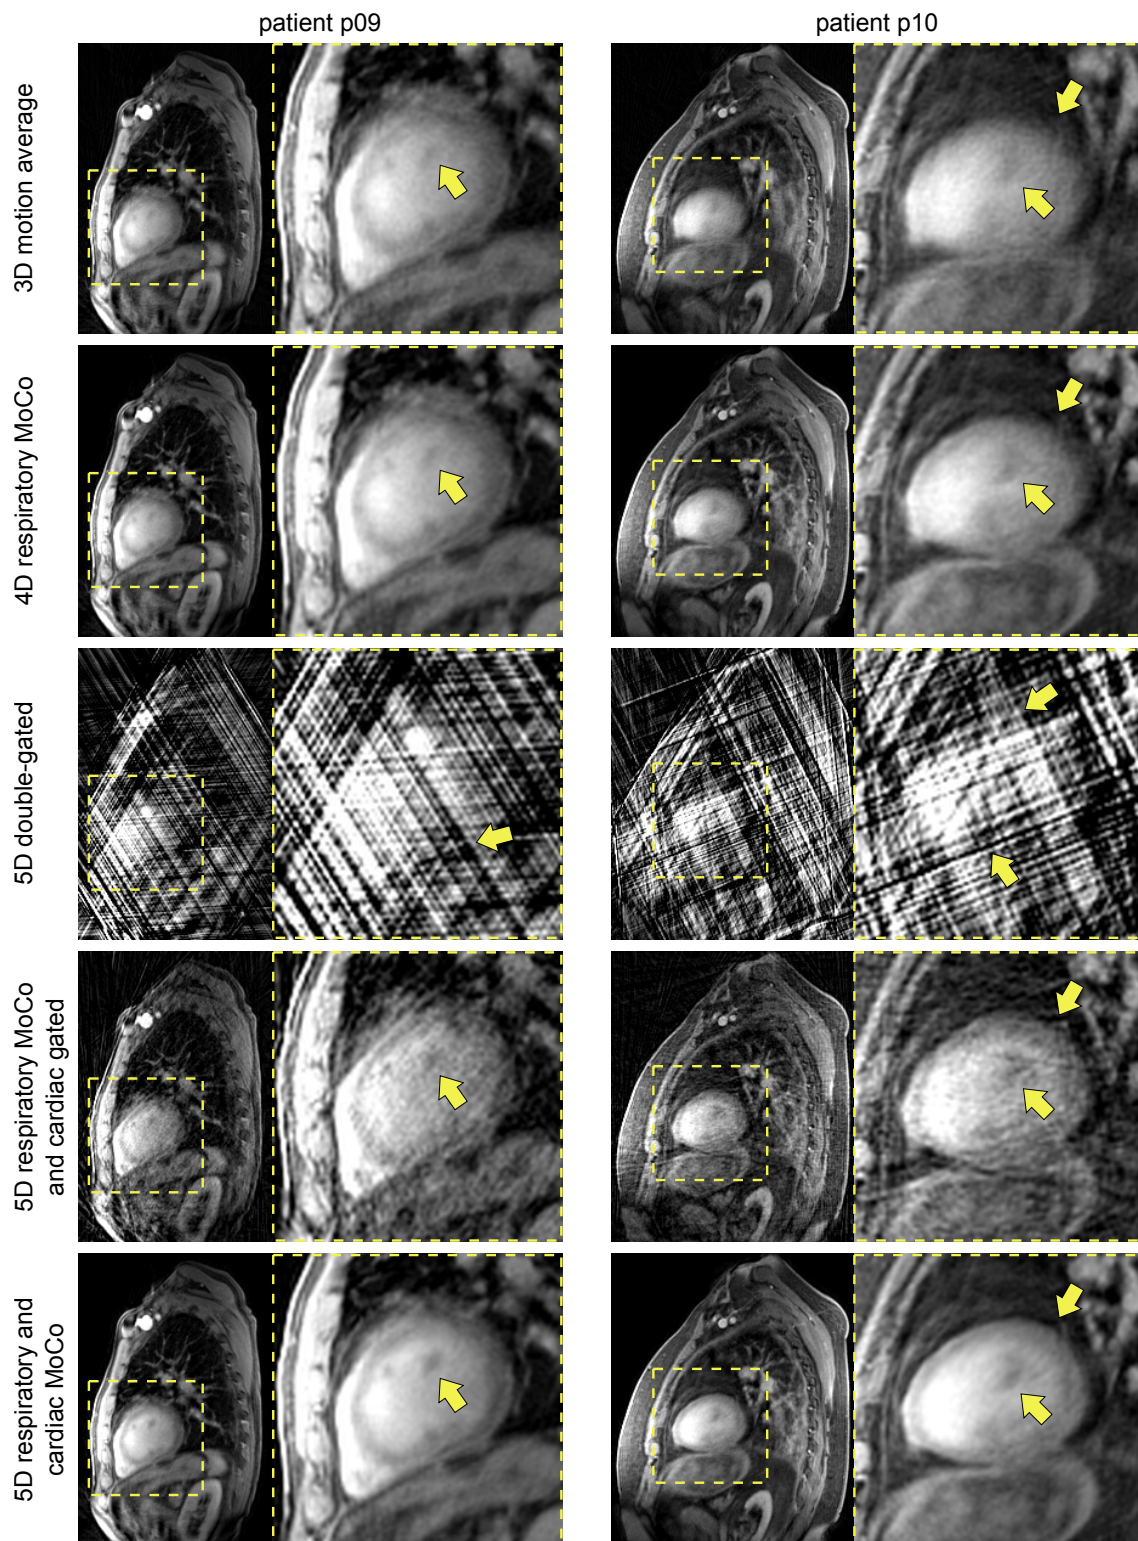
5D MRI study: MR image reconstructions of a 72-year-old male patient (p09, left) and of a 73-year-old male patient (p10, right) in sagittal orientation. A combination of end-exhale respiratory phase and a diastolic cardiac phase is shown.
